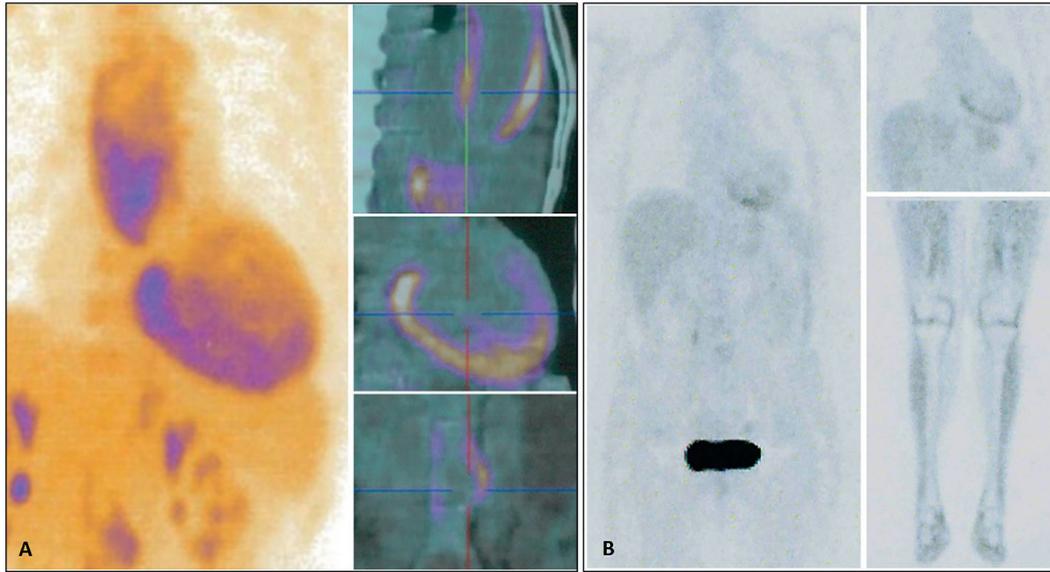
Panel A – PET-CT (Fluorodeoxyglucose) with high metabolic activity across ascending and infrarenal aorta (*). Slight diffuse activity in the myocardium (arrowhead). This imaging study was also notable for the abnormal metabolism across the carotids and lower limb arterial axis (possibly explaining the heat neck sensation and myalgias). Panel B – Whole body PET-CT (Fluorodeoxyglucose) after one-year treatment: complete resolution with normal metabolic activity across myocardium, ascending and infra-renal aorta, carotids, and lower limb axis.
